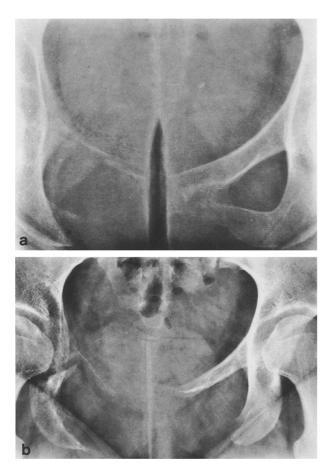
Radiographs of the patient in 1985 (a) and 1986 (b)
